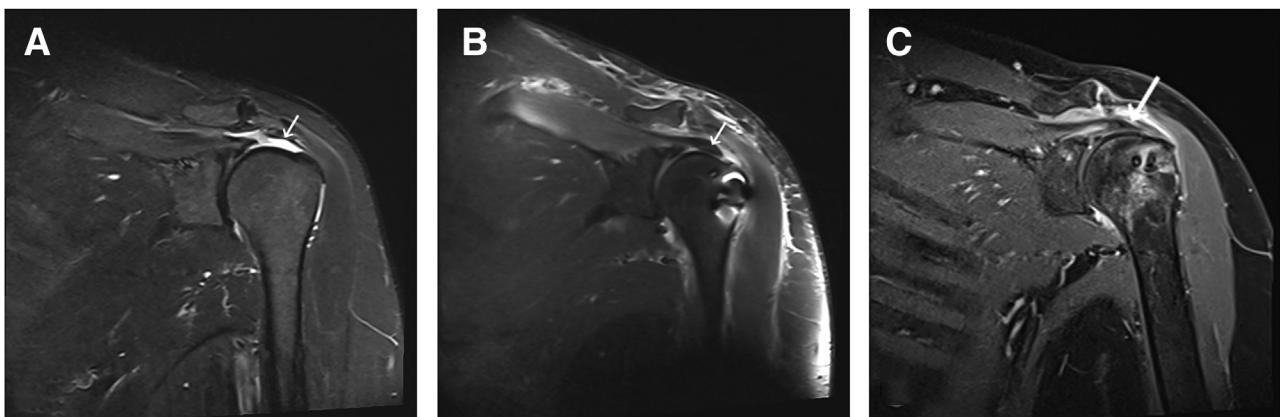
(A) Preoperative magnetic resonance imaging (MRI). The arrow indicates an MRCT. (B) MRI at 2 days after surgery. The arrow indicates the fascia lata graft. (C) MRI at 6 months after surgery. The arrow indicates the FL graft. (FL, fascia lata; MRCT, massive rotator cuff tear.)
